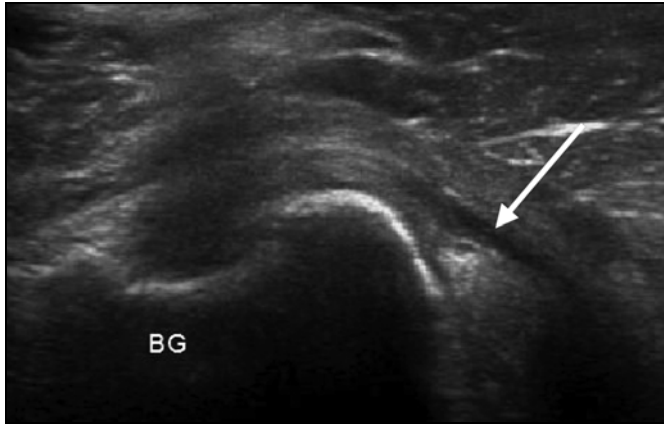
Long head of biceps tendon dislocation. Transverse sonogram shows medial dislocation of long head of biceps tendon (arrow) out of bicipital groove (BG) during external rotation of glenohumeral joint.
